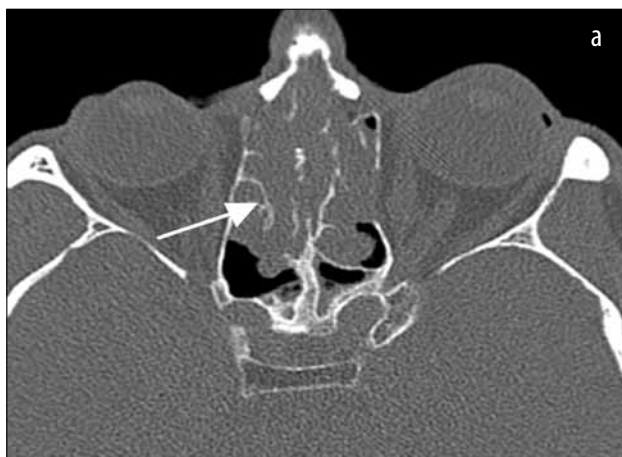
Cranio-facial CT scan, axial (a) and coronal (b) slices: ethmoid bony partitions – nidus for persistent mucosal inflammation.
